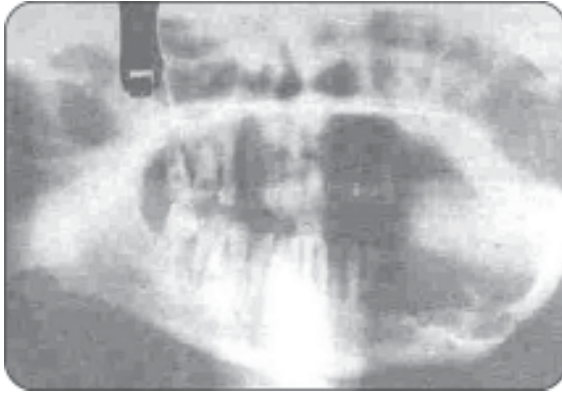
Radiographically ameloblastoma producing large multilocular radiolucency with scalloped margin
